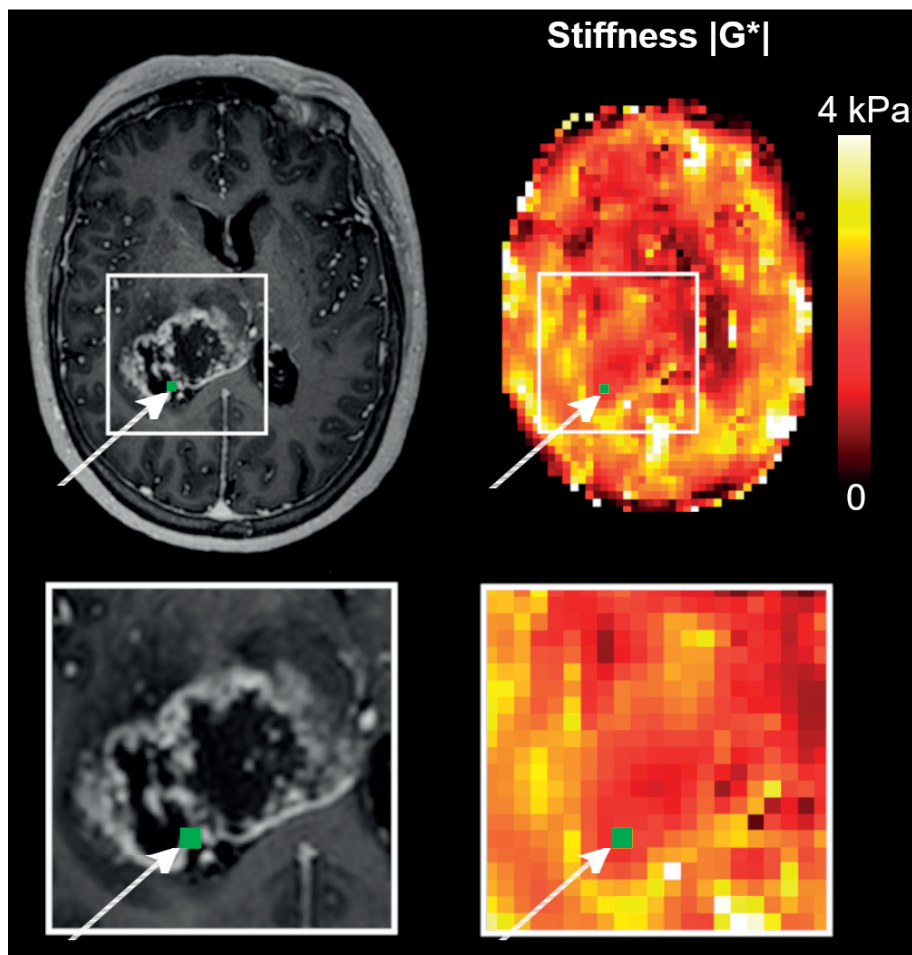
Example of MRE imaging in Paper III. The location of the tissue biopsy is shown in green in the contrast-enhanced T1-weighted image (CE-T1w) and the MRE stiffness map ($|G^*|$).
